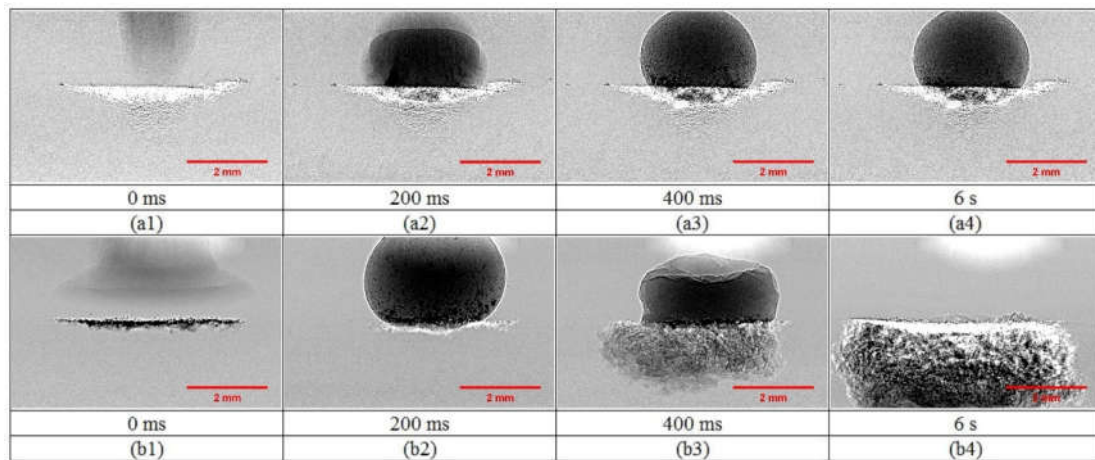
Time sequence X-ray images of the granulation process for APAP powder with water as a liquid binder released from 2.5 cm at volumes of (a1-a4) 10 μ l and (b1-b4) 15 μ l.
